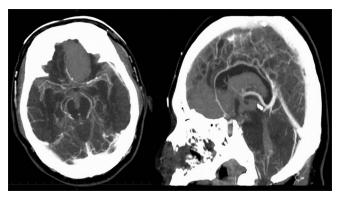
Preoperative maximum intensity projection (MIP) image of computed tomography angiography (CTA). MIP image of CTA demonstrating a small saccular vasculature in the A1–A2 junction. The vascular structure is in contact with the large hematoma
